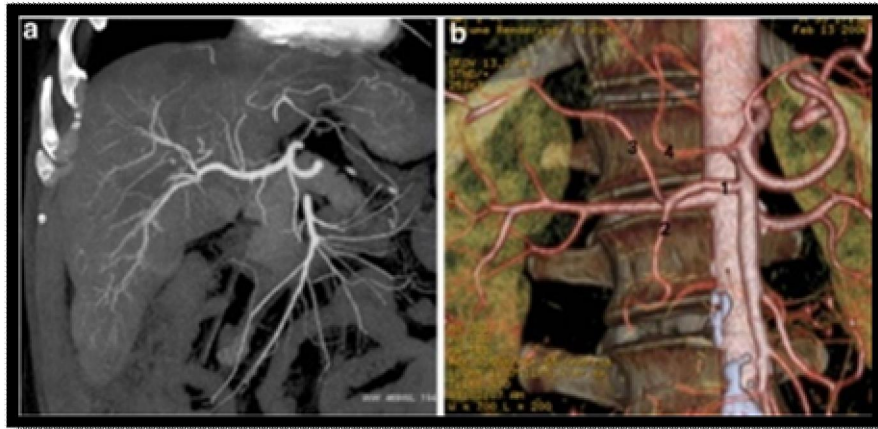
(A) MIP-reconstructed CT angiography of the hepatic artery (B) Volume-rendered CT angiography showing an abnormal origin of the common hepatic artery with the left hepatic artery arising from the celiac axis of the superior mesenteric artery. Legend: 1, common hepatic artery; 2, gastroduodenal artery; 3, right hepatic after 4, left hepatic artery⁽⁶¹⁾.
